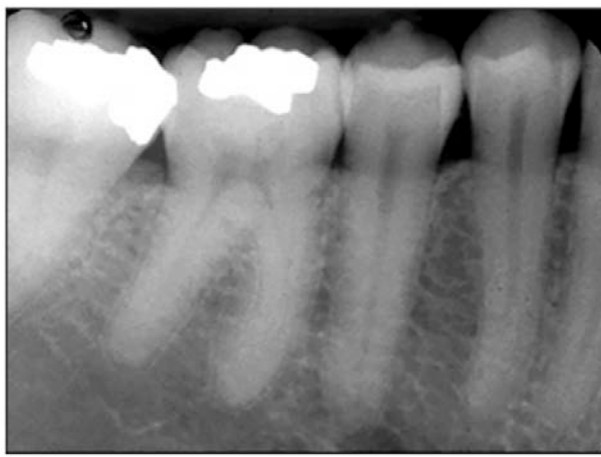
Periapical radiograph of mandibular posterior bone pattern.
